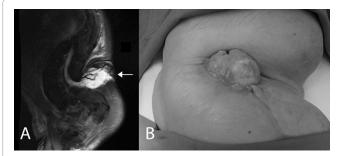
(A) Sagittal MR image T2 of the lumbar spine demonstrating the myelomeningocele with surrounding fluid collection (white arrow). (B) The preoperative lumbosacral region of the patient with the open myelomeningocele.
